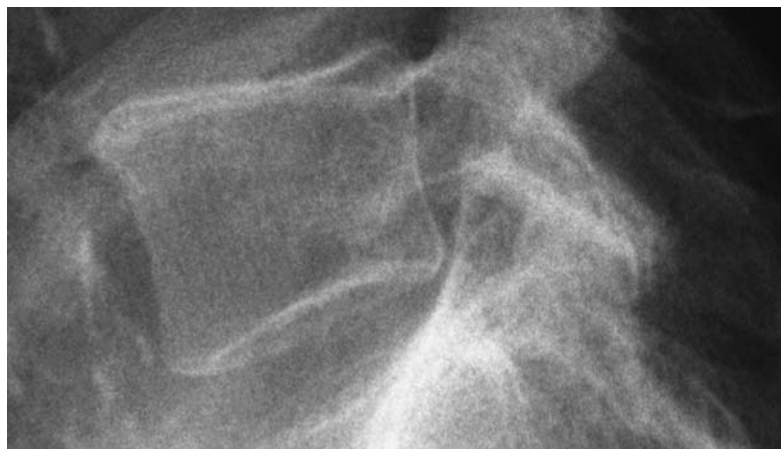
Lateral X-ray of the 5th vertebra shows increased lucency, cortical thinning and vertical striations at the vertebral body. These findings are suggestive for osteoporosis
